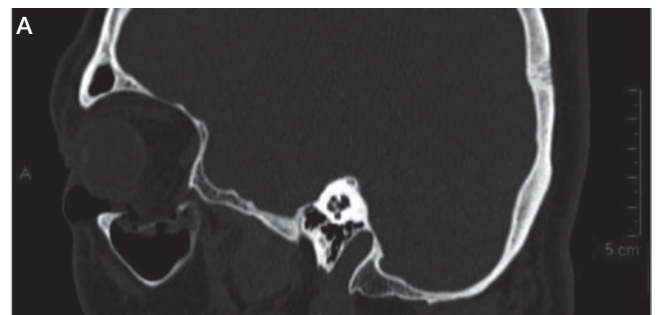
CT scans showing reduction and osteosynthesis of bilateral orbital floor fracture.
